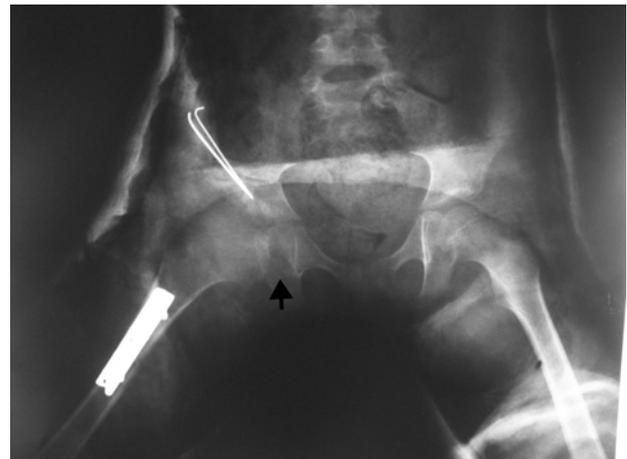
Early postoperative anteroposterior pelvic radiograph. There is widening of the medial joint space (black arrow).
